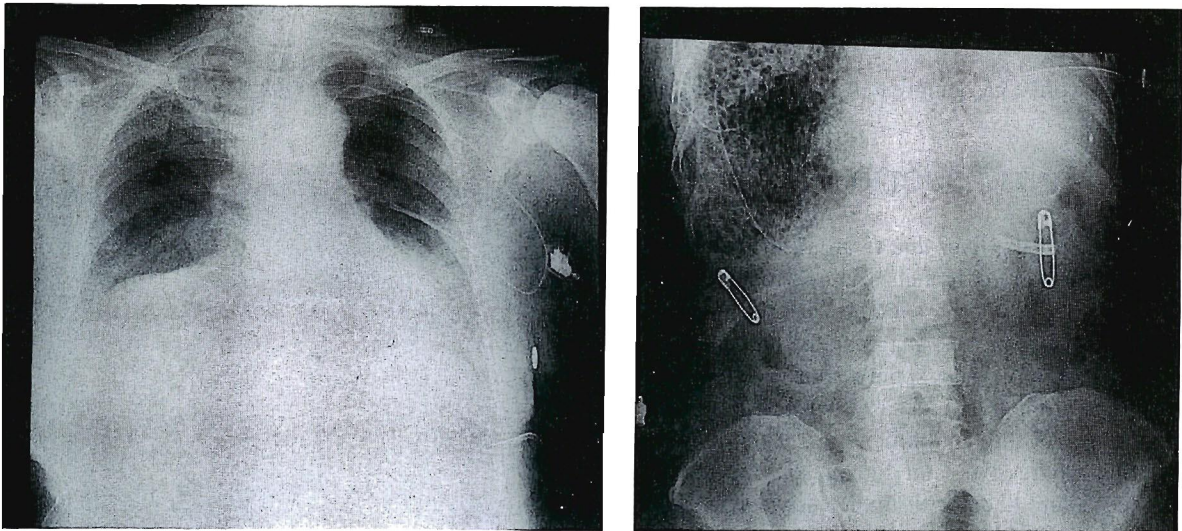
Plain chest and abdominal radiographs disclosed a mottled gas pattern in the liver area (right ; chest) (left ; abdomen).
